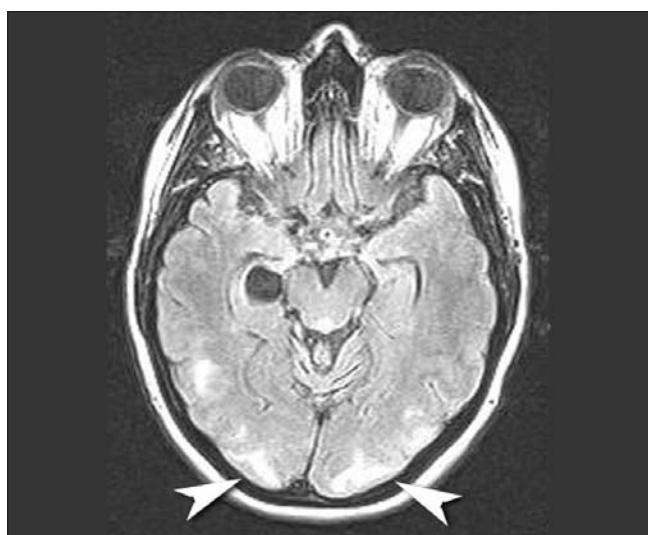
Magnetic resonance image showing bilateral marked changes in the subcortical white matter, predominantly in the occipital lobes (arrowheads).
